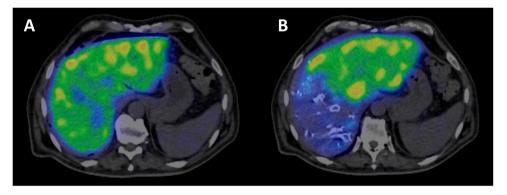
Representative images of pre- (A) and post-DVE (B) Tc-99m mebrofenin SPECT-CT scans.
